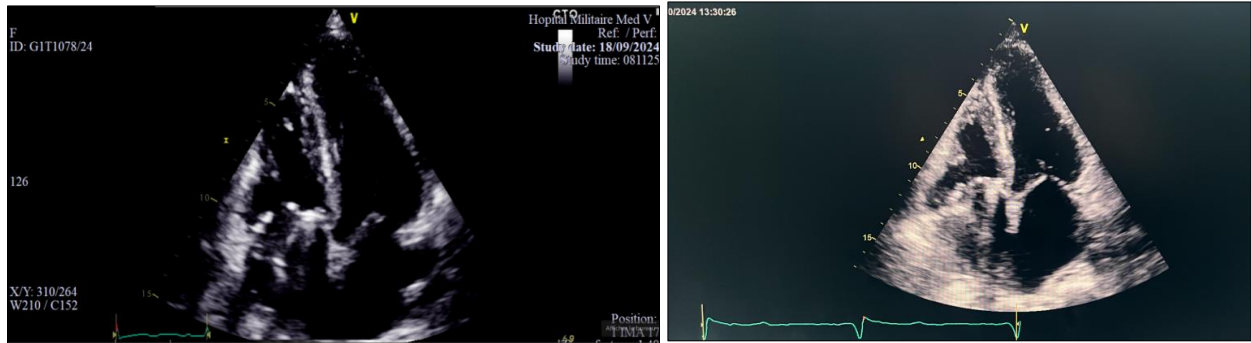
Echocardiographic images in apical four-chamber view showing a thickened tricuspid valve, fixed in a semi-open position
